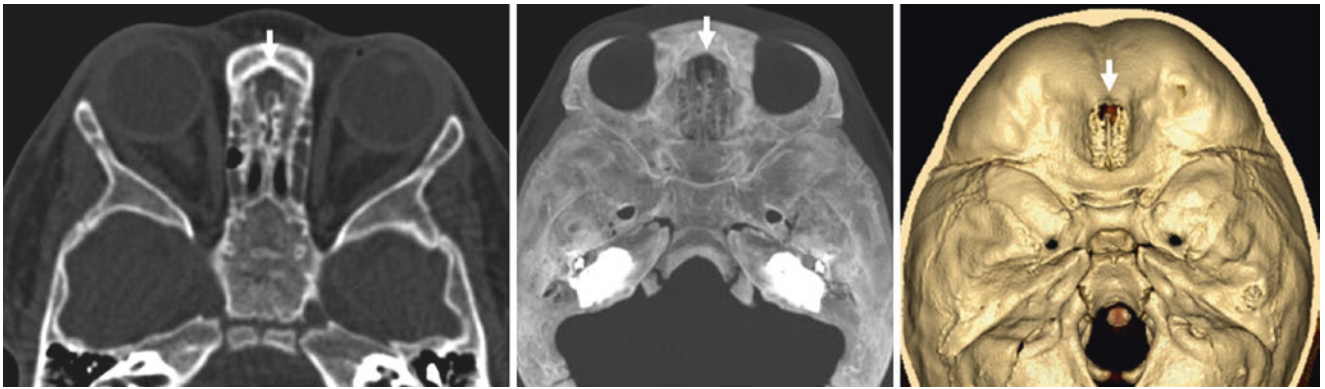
An 11 month old with a sizeable but normal foramen cecum on axial CT (*left*), 24 mm MPR (*middle*) and 3D superior view (*right*)
